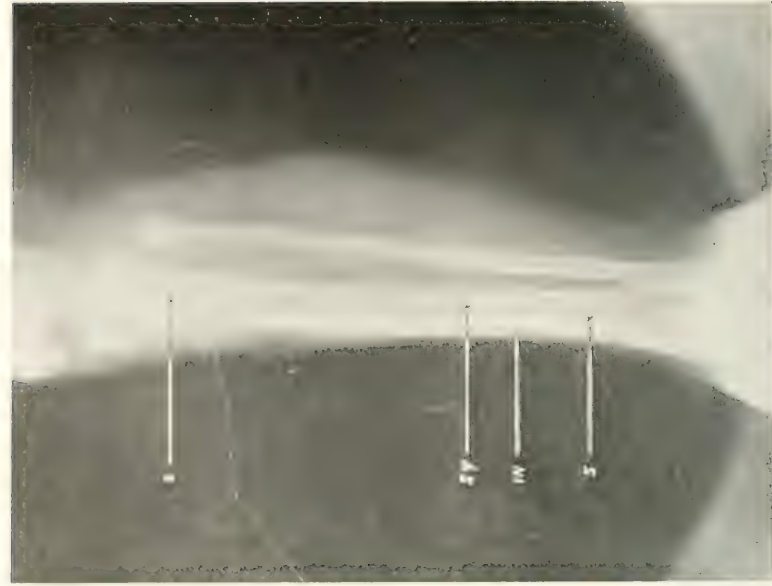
Clinical case No. 10. X-ray December 8, 1919, previous to operation. *Sy.*, sequestrum; *I.n.*, involucrum; *N.*, separation zone.
